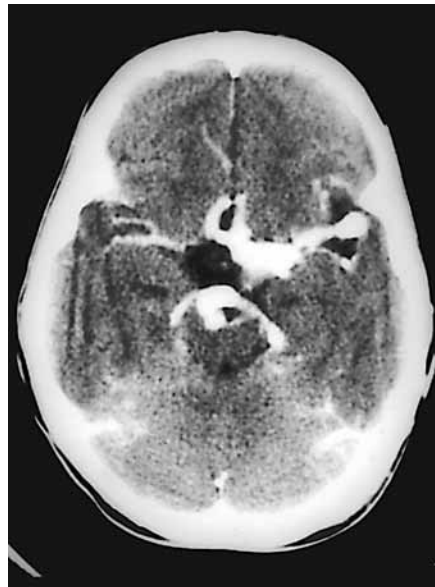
Contrast-enhanced CT in patient 2 revealing fusiform dilatation of much of the circle of Willis.
